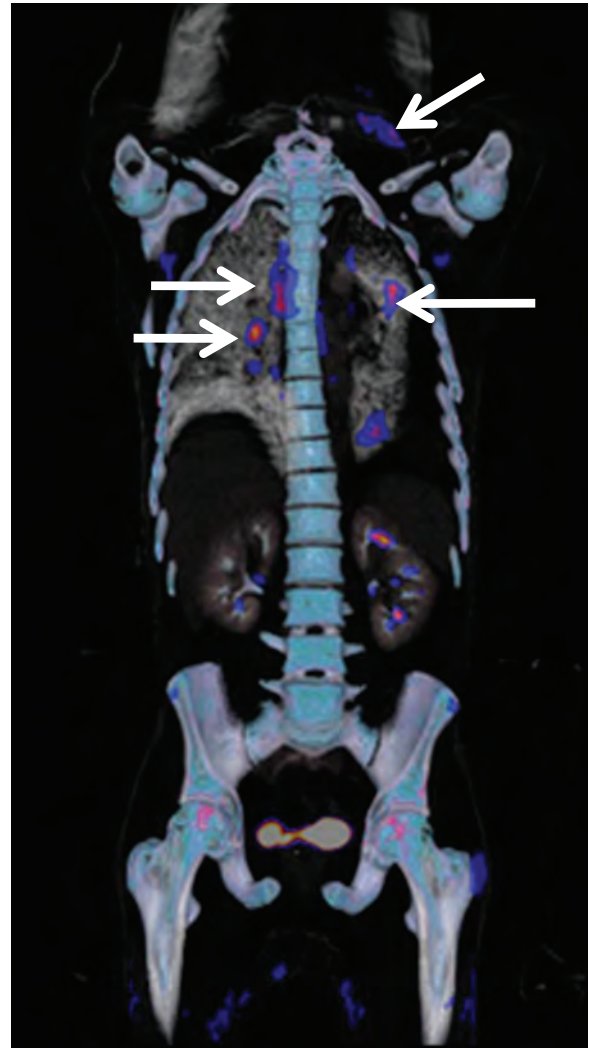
The figure shows tuberculosis lymphadenitis. ^{18}F -FDG-fused PET/CT coronal view. Arrows indicate ^{18}F -FDG uptake in left supraclavicular, right hilar and mediastinal nodes, and uptake in the left lung parenchyma compatible with active disease.
